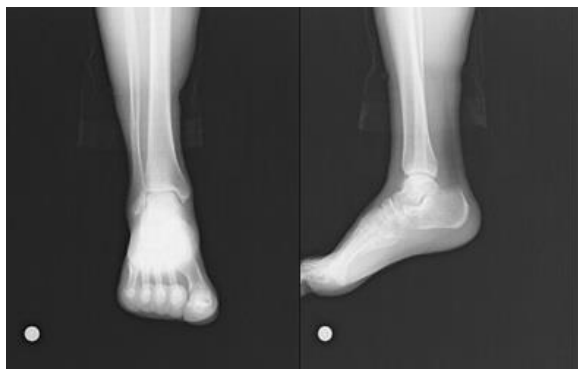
Preoperative ankle anterior-posterior and lateral radiography
